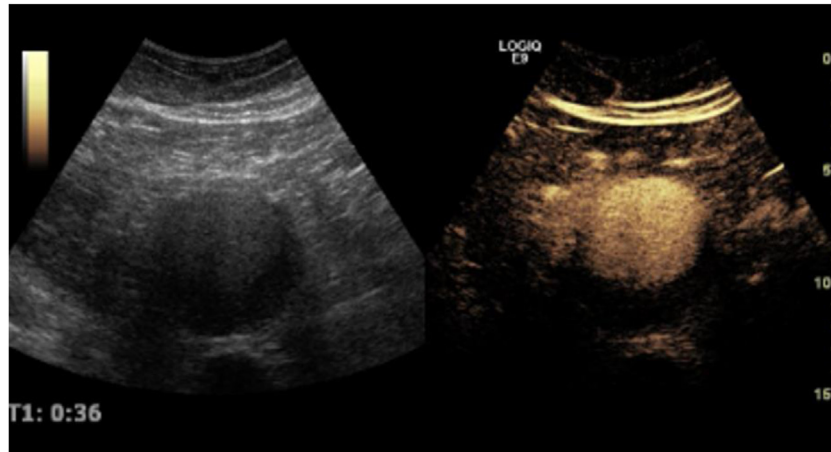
B-mode ultrasound (US) of an abdominal aortic aneurysm (AAA) (left). Contrast-enhanced visualization of the AAA before microbubble disruption by US waves (right). Microbubble disruption refers to the bursting of microbubbles when exposed to US at a certain frequency. After disruption, differential uptake of different areas of a blood vessel (aneurysm in this case) may indicate a stable vs. unstable aneurysm wall.
